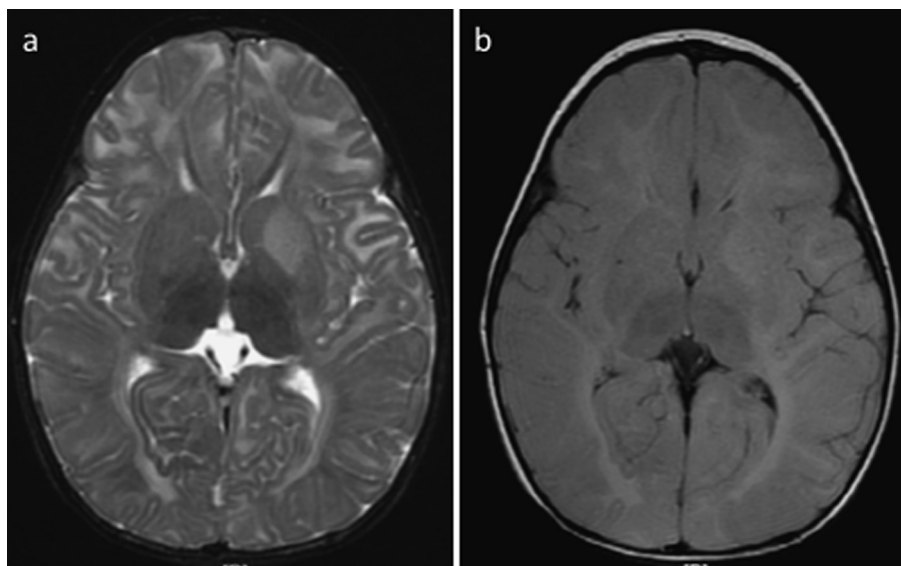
Brain MRI of the index case. Axial images, T2-weighted image (TE 80 msec, TR 6000 msec) (a) and FLAIR image (TE 84msec, TR 9002 msec) (b), show hyposignal intensity in the bilateral thalami compared to the cerebral cortex, and hypersignal intensity in the cerebral white matter and the left putamen.
